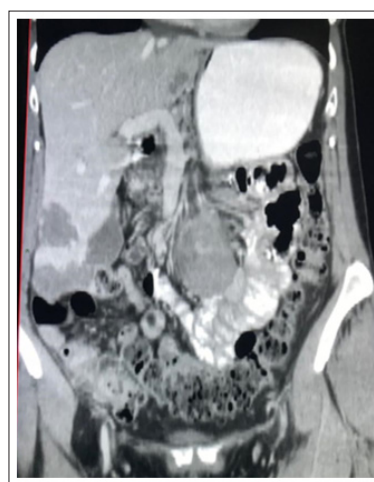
Abdominal Computed Tomography (Coronal Section). Mesenteric Lesion and Multiple Hemangiomas. It Shows a Mesenteric Lesion with Central Contrast Filling, Transit of the Distal Jejunum
